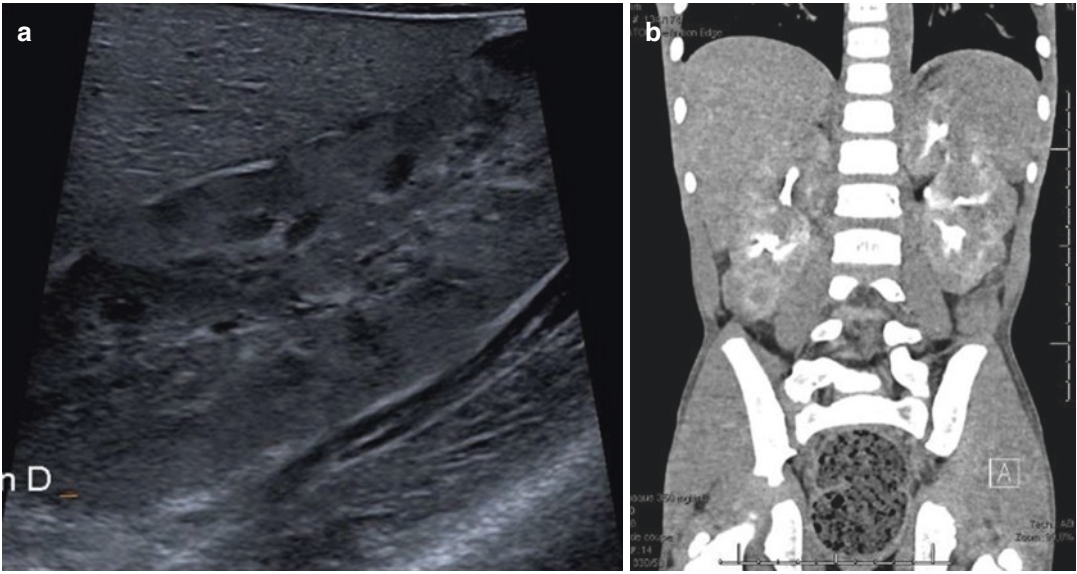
Leukemic infiltration of the kidneys. (a) US Sagittal scan of the kidney. The kidney appears slightly enlarged. Its echogenicity appears inhomogeneous with diffuse poorly visible nodules. (b) CE-CT of the abdomen
